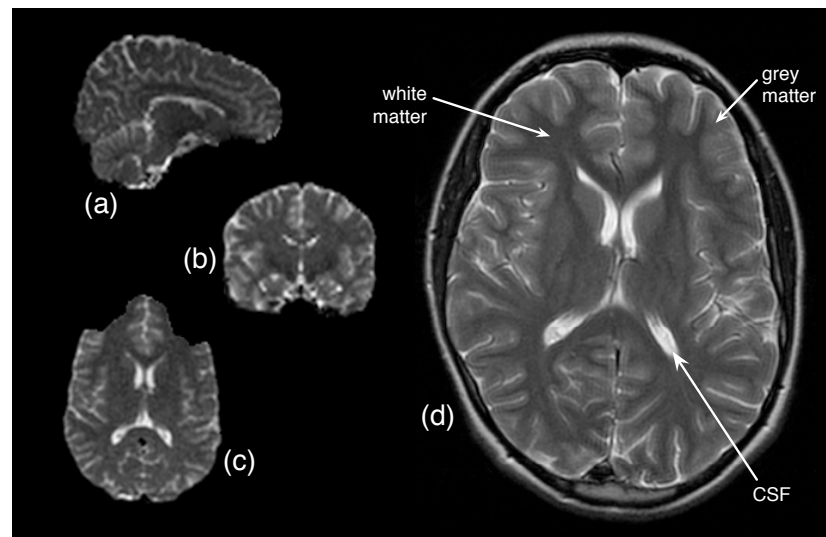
Magnetic resonance images of the brain, shown in sagittal (a), coronal (b) and axial (c) planes, perpendicular to the left–right, anterior–posterior and superior–inferior directions respectively. The high resolution axial image (d) shows clear contrast between the three main tissue types. By radiological convention, the left side of the brain from the patient’s perspective is shown on the right side of all images.
